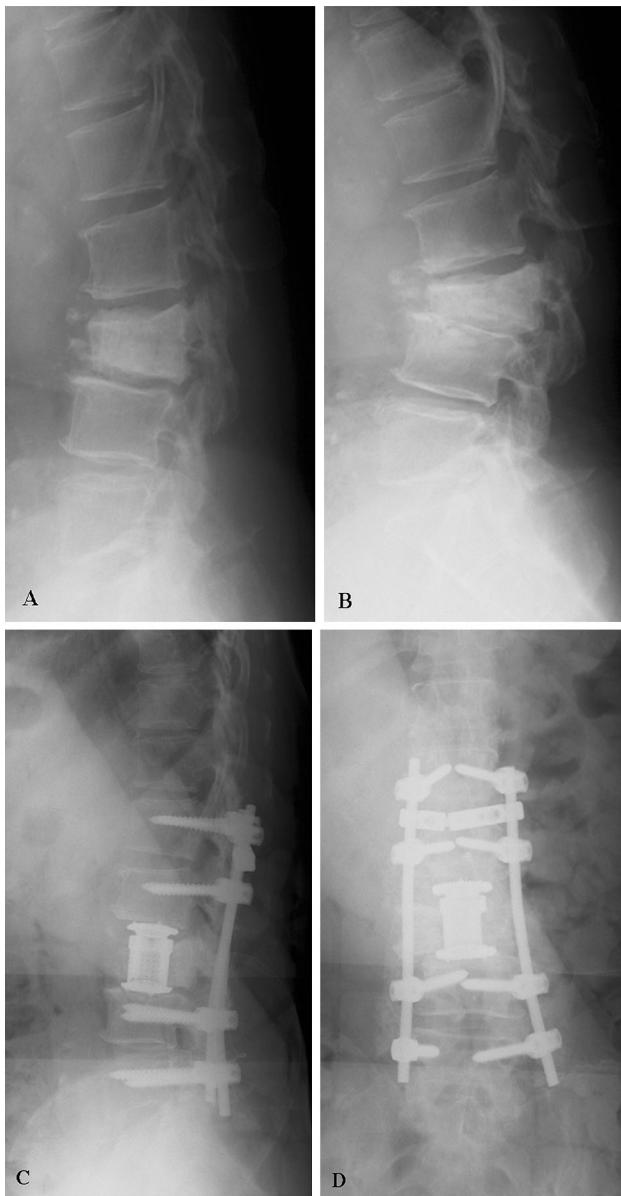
a Plain radiograph taken during the patient's first visit to the hospital. b Compression fracture after the CIRT. c, d Post-operative lateral and AP views
